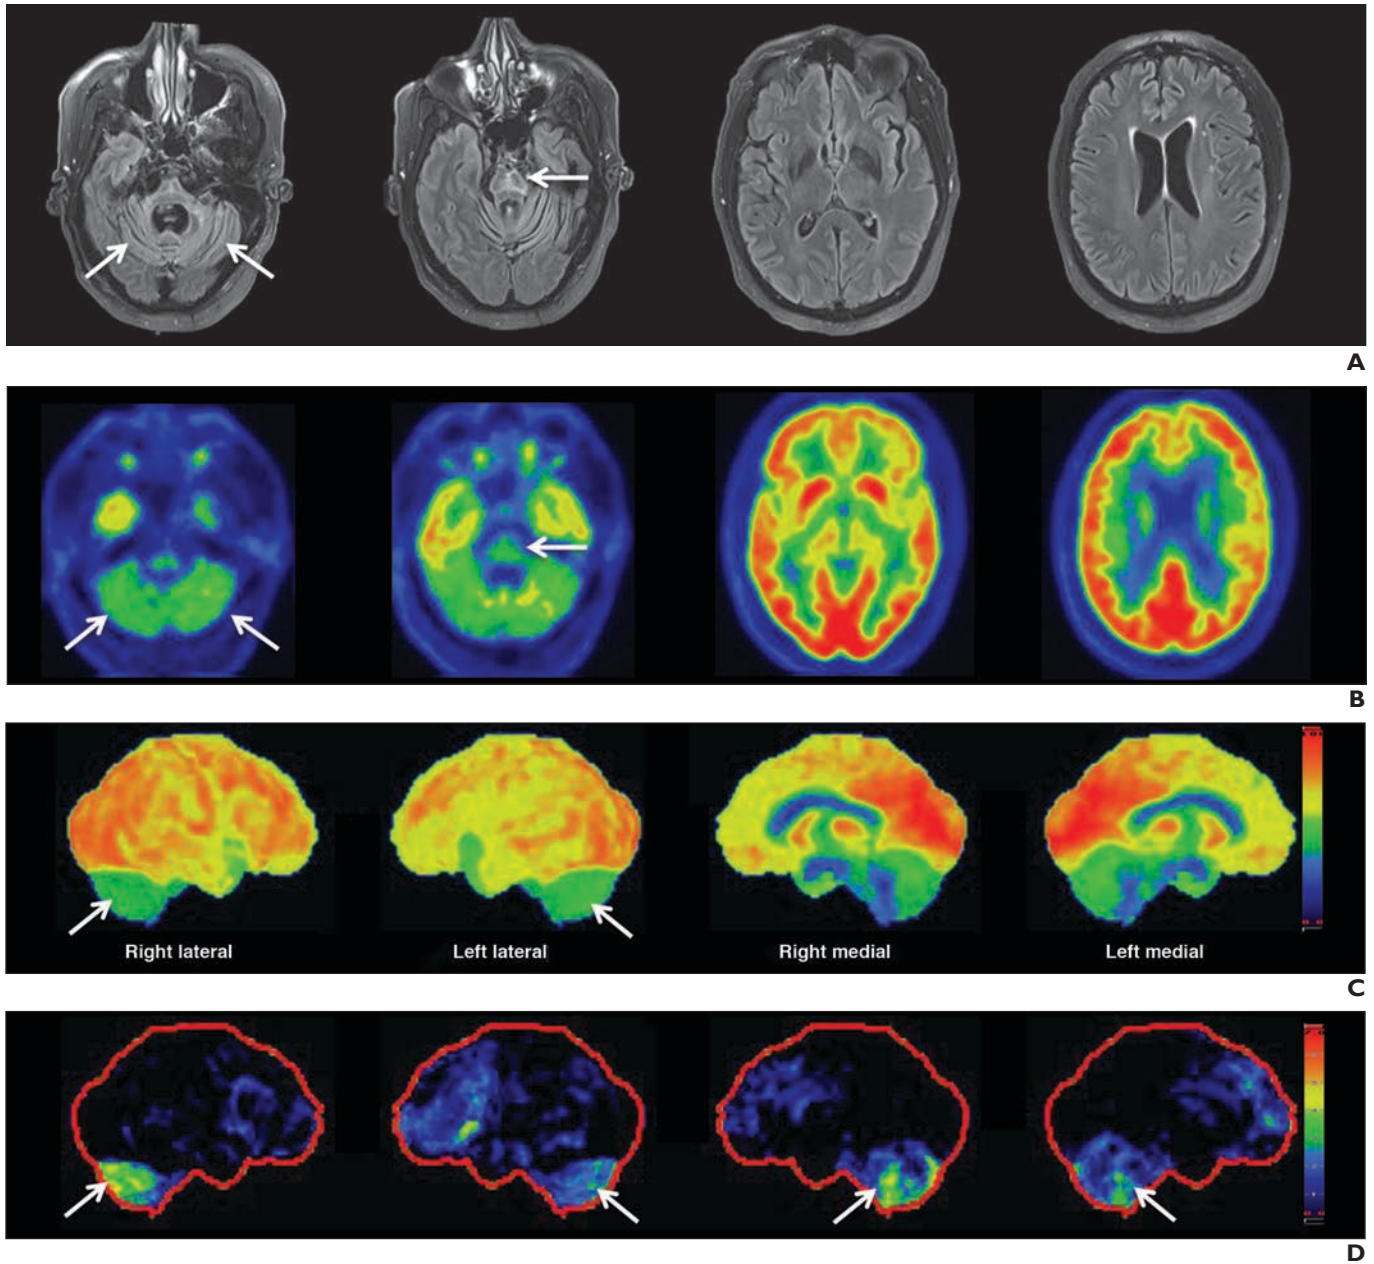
Multiple-system atrophy (MSA-C) in 56-year-old man who presented with mild parkinsonism, cerebellar ataxia, and autonomic dysfunction. A, Axial T2-weighted FLAIR images (*images from left to right*: skull base to vertex) show marked focal atrophy of midbrain and both middle cerebral peduncles, ex vacuo dilatation of fourth ventricle, and “hot cross bun” sign with cruciform T2 hyperintensity in pons (*arrows*). B–D, Axial FDG PET images (*images from left to right* [B]: skull base to vertex), 3D stereotactic surface projection maps (C), and Z-score projection maps (D) show dominant cerebellar and mild pontine hypometabolism (*arrows*) typical of subtype of MSA with predominantly cerebellar ataxia symptoms.
